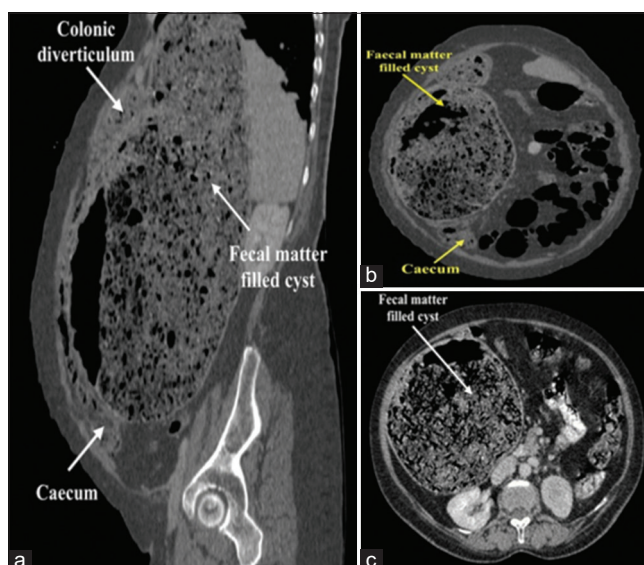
3D multi-planar reconstruction of computed tomography images on oblique sagittal, coronal, and axial plane with labelings. (a) sagittal view - top white arrow: colonic diverticulum, middle white arrow: fecal matter filled cyst, bottom white arrow: caecum. (b) Coronal view - top yellow arrow: fecal matter filled cyst, bottom yellow arrow: Caecum. (c) Axial view: white arrow - fecal matter filled cyst.
